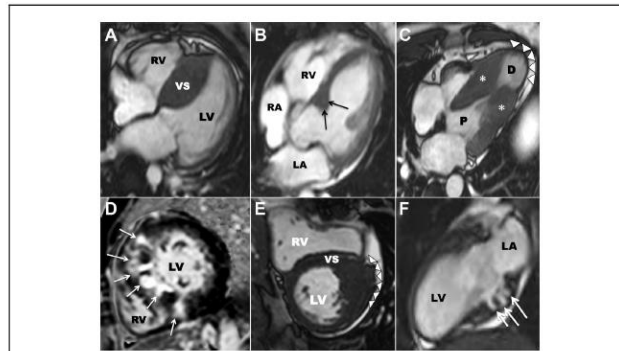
Cardiovascular Magnetic Resonance Images Demonstrate Diversity of the Hypertrophic Cardiomyopathy Phenotype
